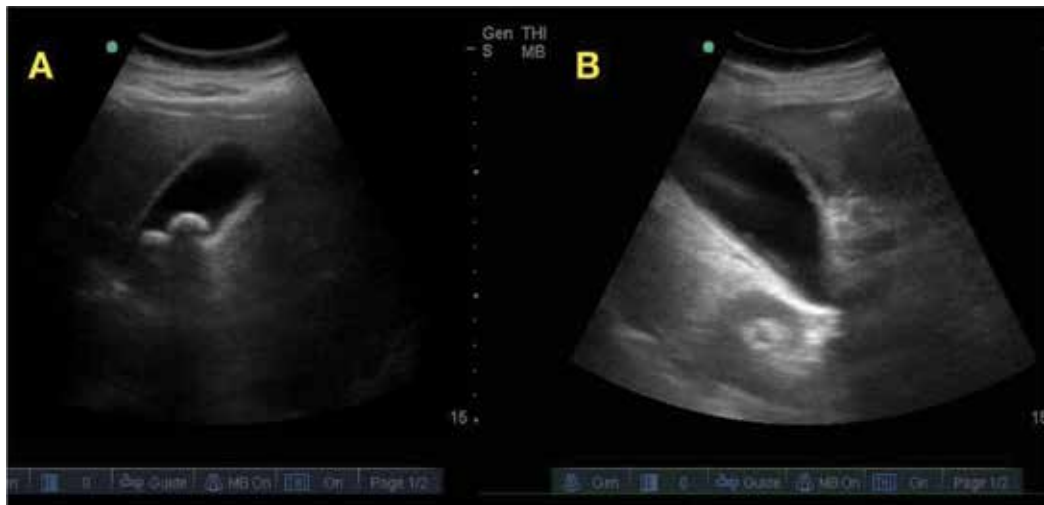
Biliary ultrasound demonstrating gallstones in (A) and cholecystitis in (B) suggested by the thickened gallbladder wall and pericholecystic fluid.
